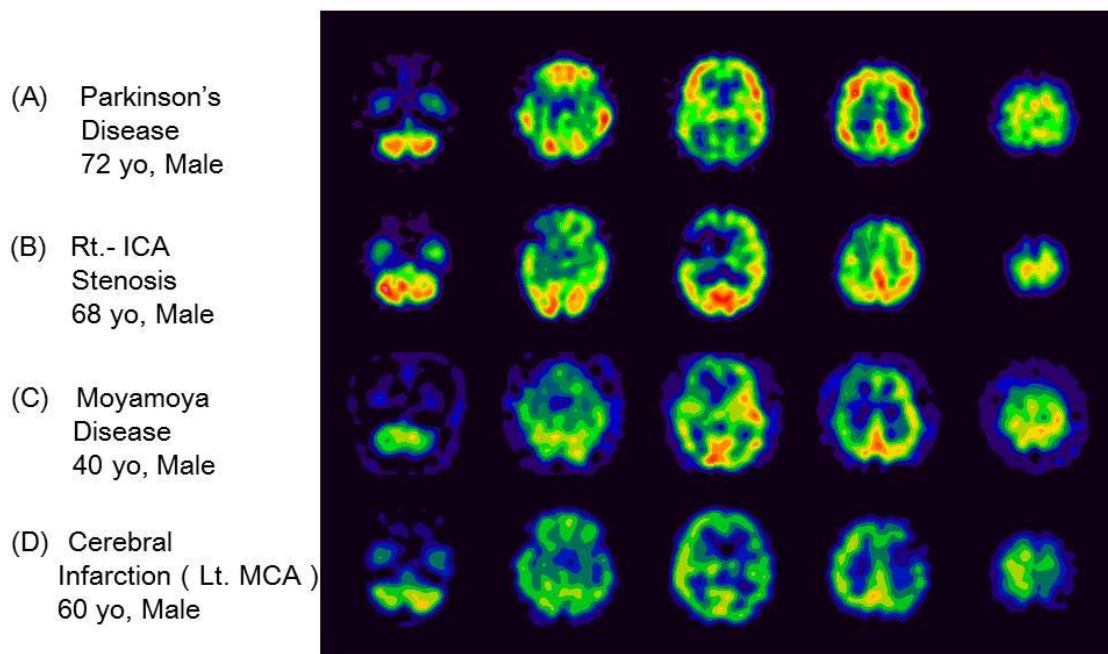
Exemplary rCBF images by ^{123}I -IMP SPECT in patients with Parkinson's disease (A), right internal carotid artery (ICA) stenosis (B), moyamoya disease (C), and cerebral infarction (left middle cerebral artery (MCA)) (D).
